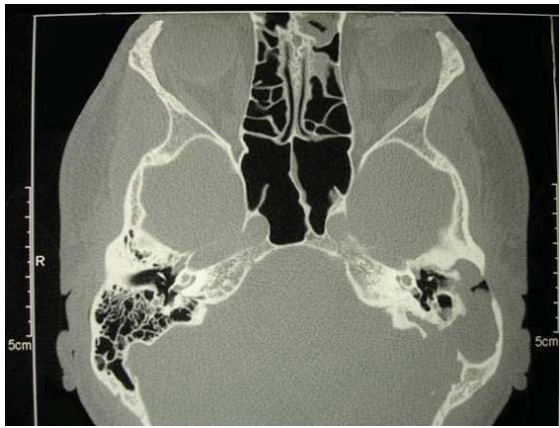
Case 1: Preoperative computed tomography of the right mastoid area. Coronal view of temporal bone showing the lesion destroying the posterior canal wall of auditory canal.
